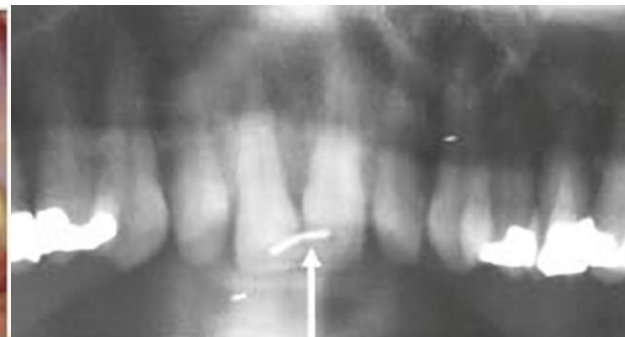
The radiograph and splint with the left upper incisor
